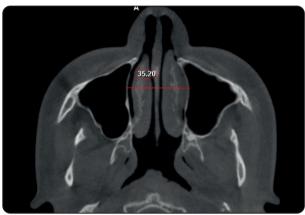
The maximum intermaxillary distance on an axial CBCT image.
